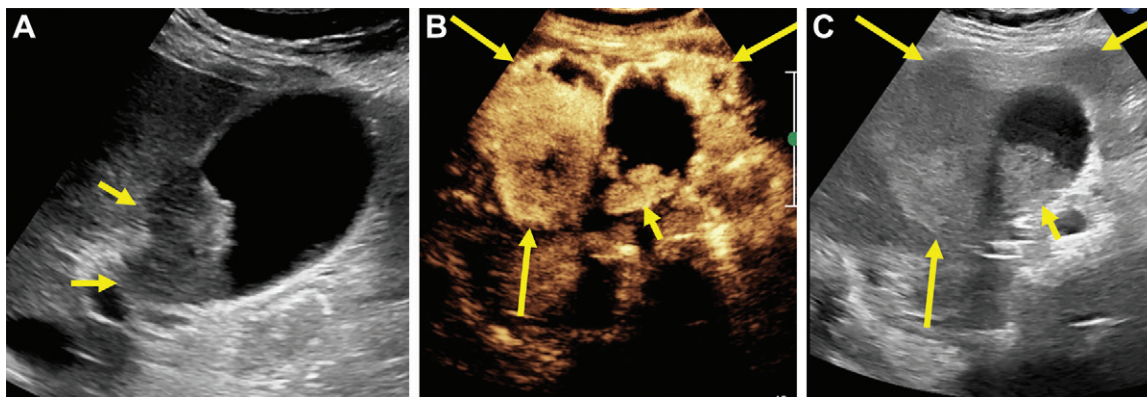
Frank liver invasion and liver metastases. (A) Gray-scale US image shows a 23-mm hypoechoic mass with frank direct liver invasion (arrows). Given findings of suspected malignant invasion, the Society of Radiologists in Ultrasound algorithm should not be used, and referral to an oncologic specialist would be recommended. (B) Contrast-enhanced and (C) corresponding gray-scale US images obtained 6 months later, as patient was lost to follow-up, show an enlarging polypoid mass (now 33 mm) (short arrow). Microbubble contrast (B) demonstrates heterogeneous enhancement and ulceration and outlines multiple liver metastases (long arrows in B and C).
